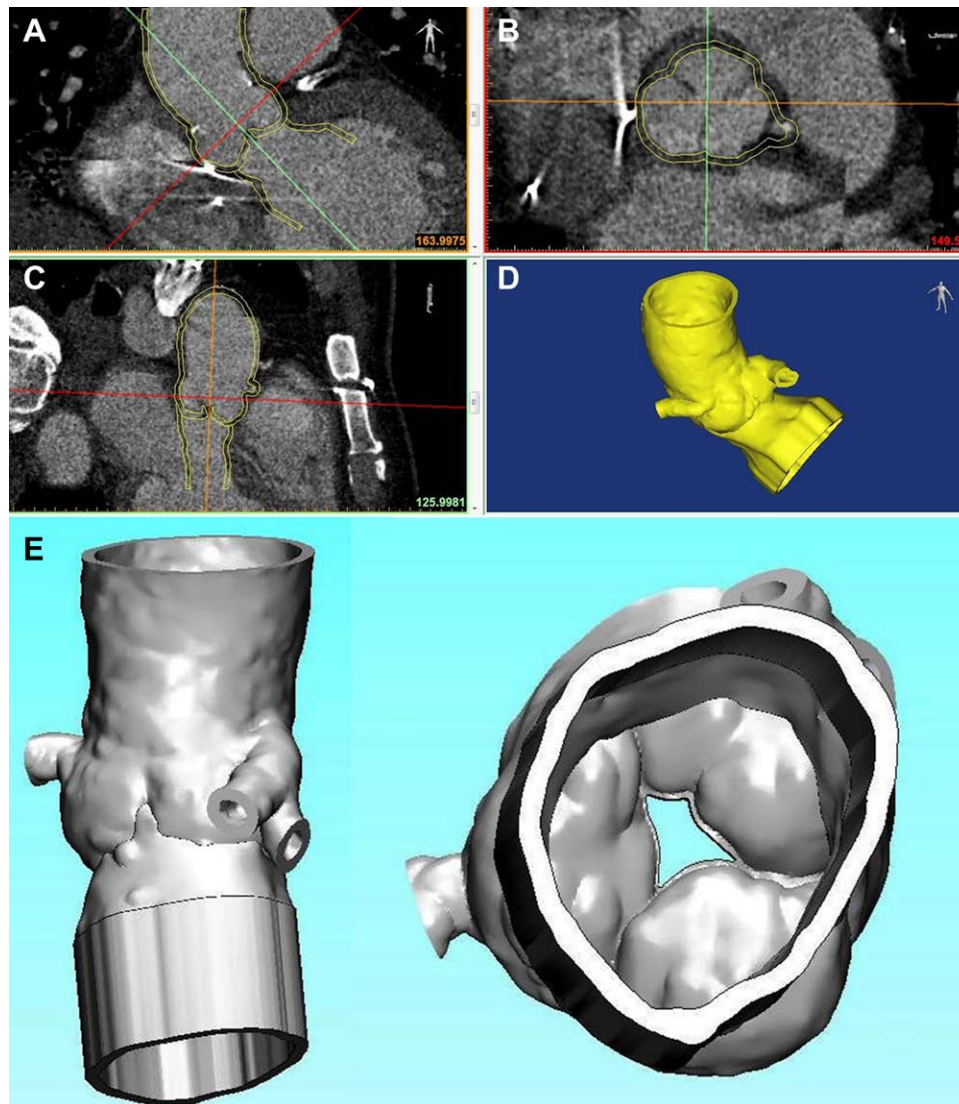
A–C: Computed tomography scan segmentation with Mimics 18.0 software (Materialise): 1 cm of thickness was added to the inner surface of the aortic root after having isolated the blood. This thickness represents the aortic root wall and the valve leaflets; (D) 3D prototyping using the Mimics 18.0 software (Materialise); (E) 3D reconstruction with the 3-Matic 10.0 modeling software (Mimics Innovation Suite) employed to obtain the final models for 3D printing.
